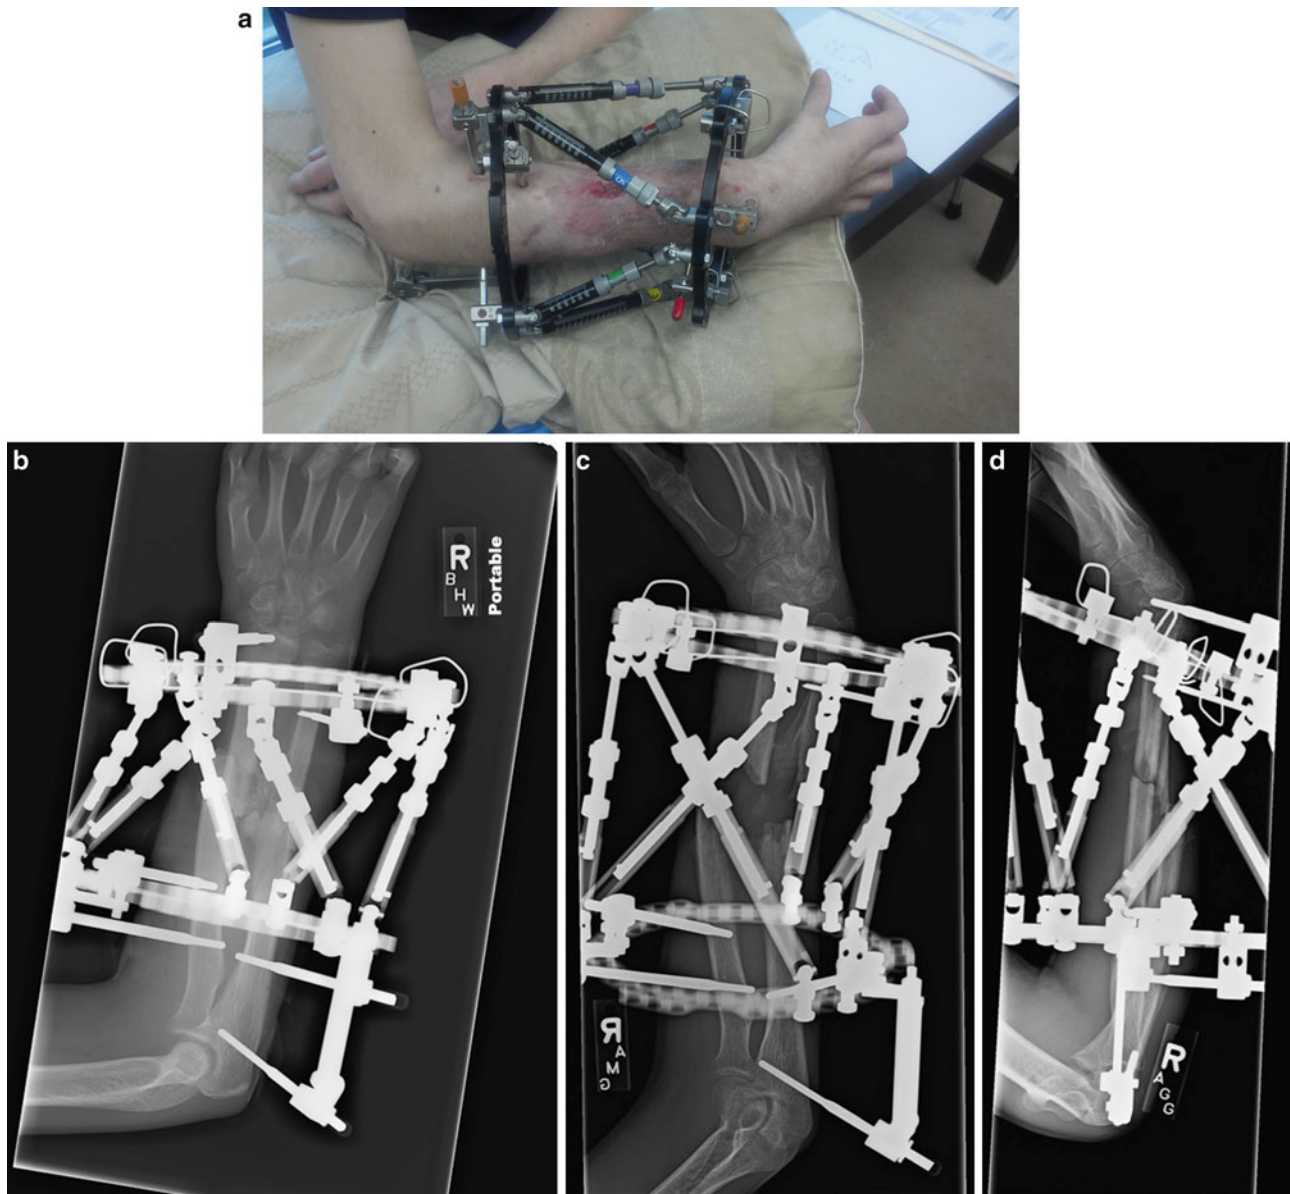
(a) Clinical photograph at 6.5 weeks postinjury and immediately after spatial frame application. (b) AP forearm radiograph immediately after spatial frame application. (c) AP forearm radiograph 4 weeks after
